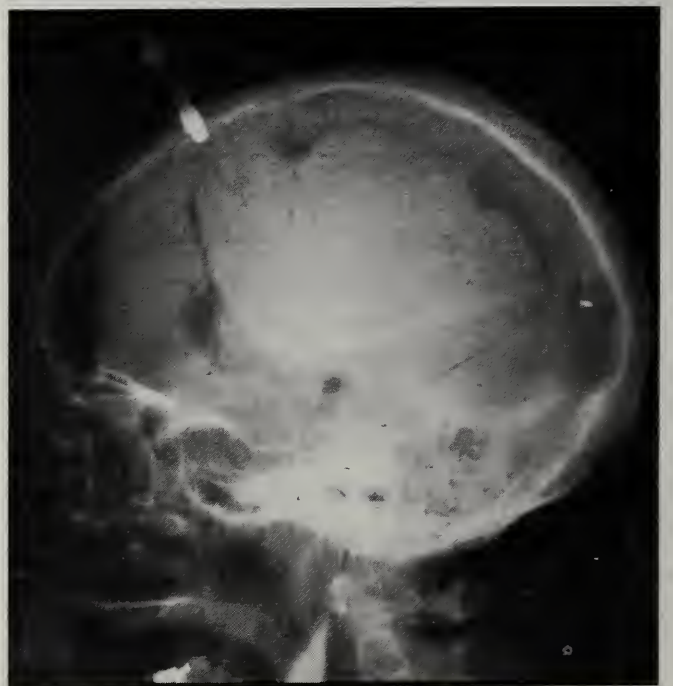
X-ray of a post-operative craniotomy patient showing a subarachnoid wick monitor in place.
